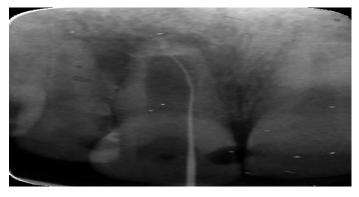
File-up radiography. the file no 15 is blocked by the hard tissue present at the apical level.
